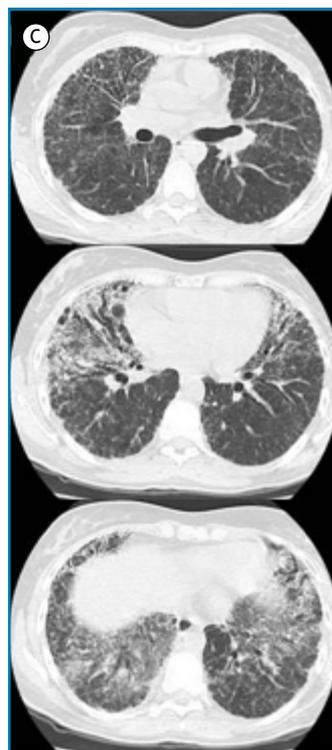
Spirometry (in A), arterial blood gas analysis (in B), and chest CT (in C) in a 23-year-old woman with complaints of progressive dyspnea following chronic nitrofurantoin use. In addition to severe restriction on spirometry and interstitial lung disease with craniocaudal distribution, right-to-left shunt measured during 100% O₂ breathing was increased in the supine position, further increasing in the upright position. BD: bronchodilator; HCO₃: bicarbonate; and PAO₂ = alveolar partial pressure of O₂.
